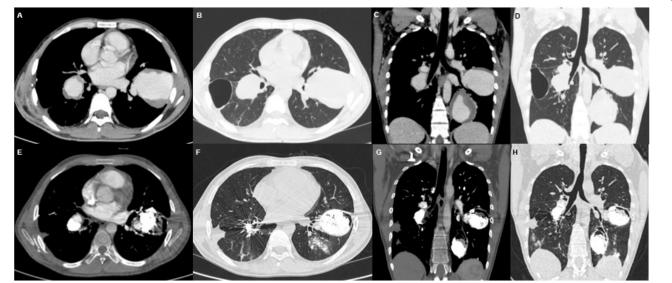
(A-D) Computed tomography scan of the chest demonstrating pulmonary aneurysms without endovascular treatment; (E-H) Pulmonary aneurysms after endovascular embolization.
